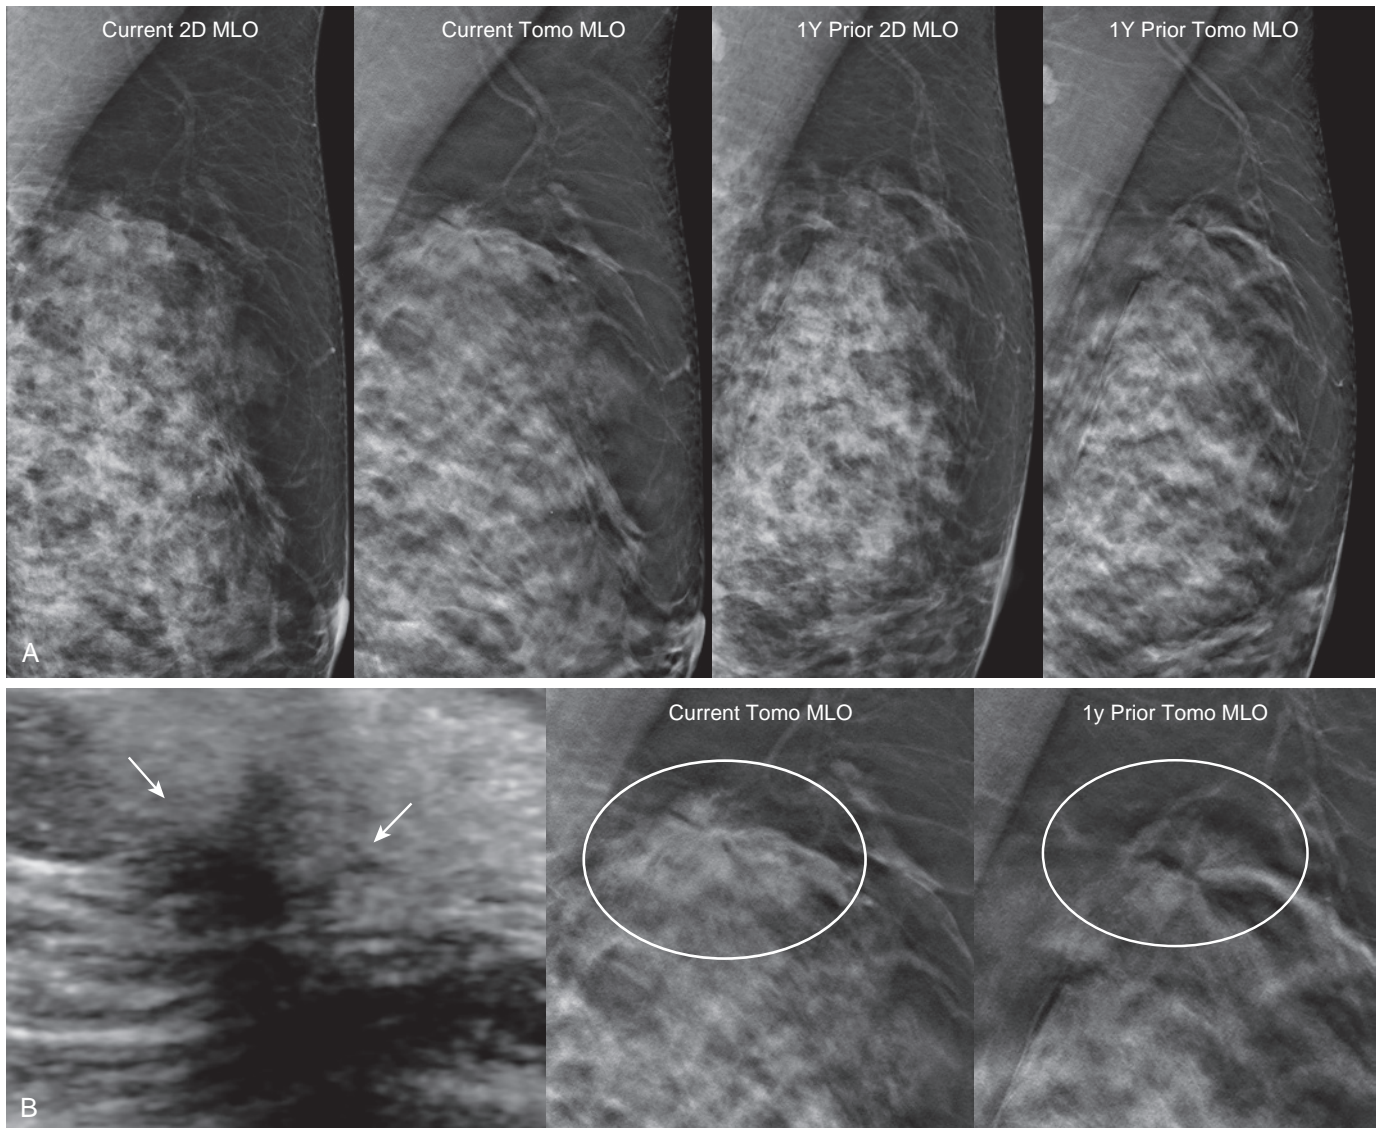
False negative tomosynthesis screening mammogram. (A) Screening mammogram in a 46-year-old woman reveals extremely dense breast tissue and was interpreted as BI-RADS 1. (B) Four months later, the patient had a screening ultrasound exam that revealed an irregular 1-cm hypoechoic mass with indistinct border (*circles*). In retrospect, a corresponding AD is seen in the left upper breast that was present on the prior mammogram (*circles*). Ultrasound-guided core needle biopsy and excision = 1.2 cm IDC, grade 2, ER/PR+, Her2–, Ki67 = 10%, 0/1 SLN. The architectural distortion was originally missed on screening, likely due to interpretation error.
